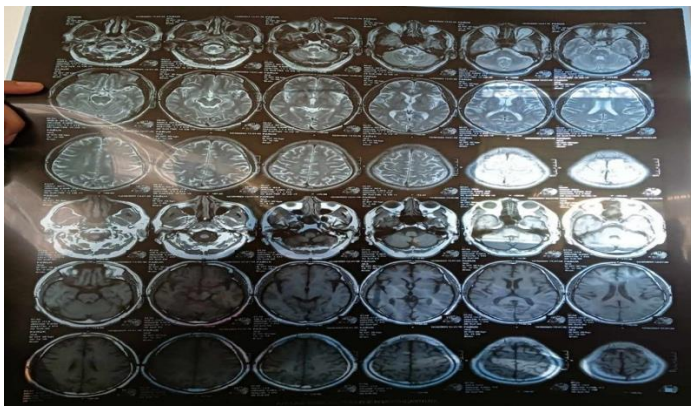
Representative sample of the digitized raw multi-slice clinical MRI film dataset collected for independent validation.
